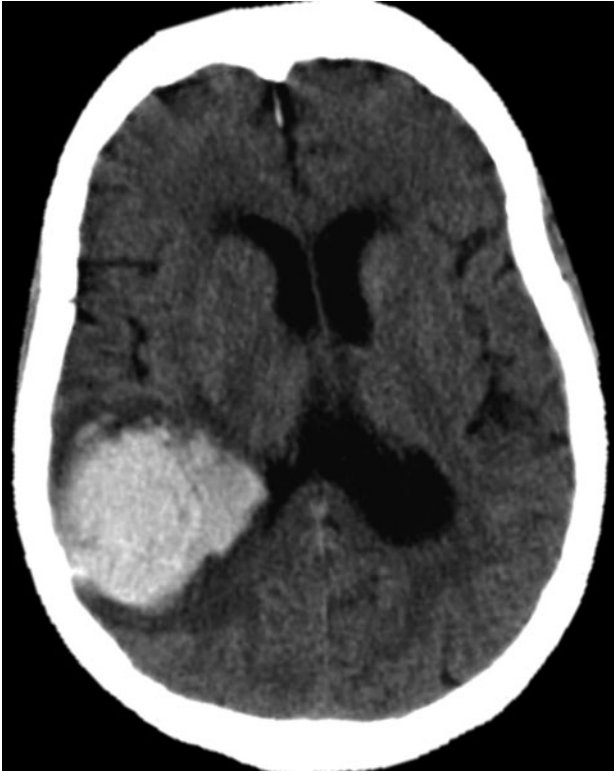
This axial non-contrast CT brain scan shows an acute large right parietal lobar haematoma, with moderately severe confluent low attenuation (leuкоaraiosis) extending from the lateral ventricles into the subcortical white matter. (Copyright David Werring.)
